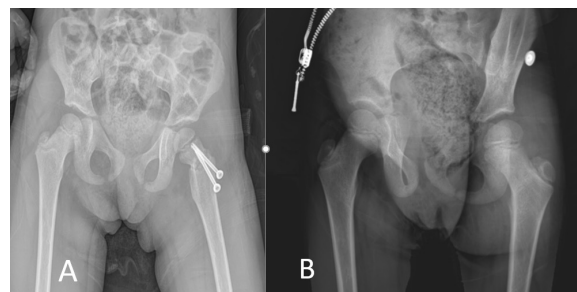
4 year-old female operated following Delbett type 3 displaced left hip fracture A. Postoperative early roentgenogram showing fair reduction(<10 degree angulation) and fixation with 2 cannulated screws B. Final roentgenogram 23 months after treatment showing union and no complication
